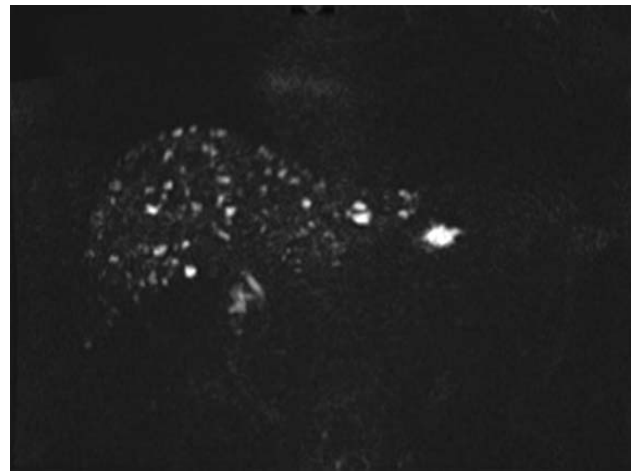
MRI of liver T2 sequence demonstrating numerous small T2 hyperintense cystic lesions consistent with biliary hamartomas.
